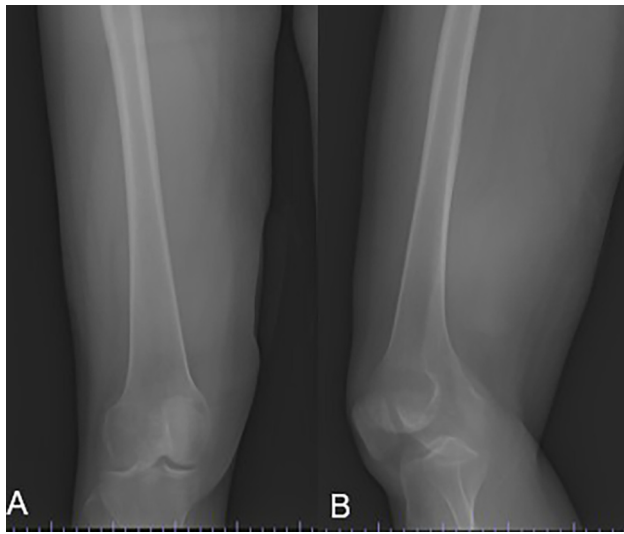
Anteroposterior (A) and mediolateral (B) radiograph of the distal right thigh showing a soft-tissue mass posterior to the femur.
